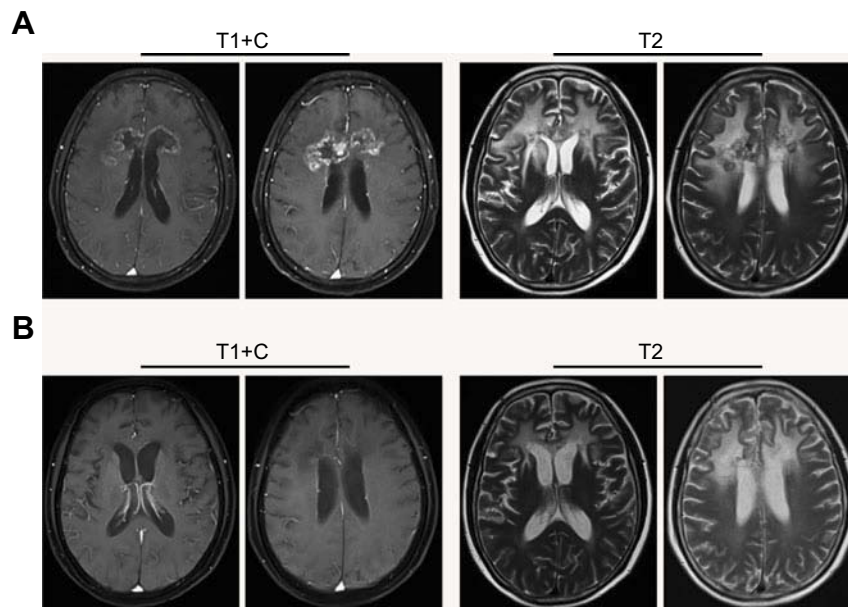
MRI scan after treating with a vascular endostatin and short-term HBO therapy. (A and B) After treating with a vascular endostatin and short-term HBO therapy, an MRI scan revealed that the clumps of matter in the bilateral frontal lobes and the genu of the corpus callosum were smaller than those on the MRI scan from 2017–07 and especially smaller than those shown on the MRI scan from 2018–06; however, the edema in the surrounding tissue was still present. Abbreviations: MRI, magnetic resonance imaging; HBO therapy, hyperbaric oxygen therapy; T1+C, contrast-enhancement T1-weighted images; T2, T2-weighted images.
